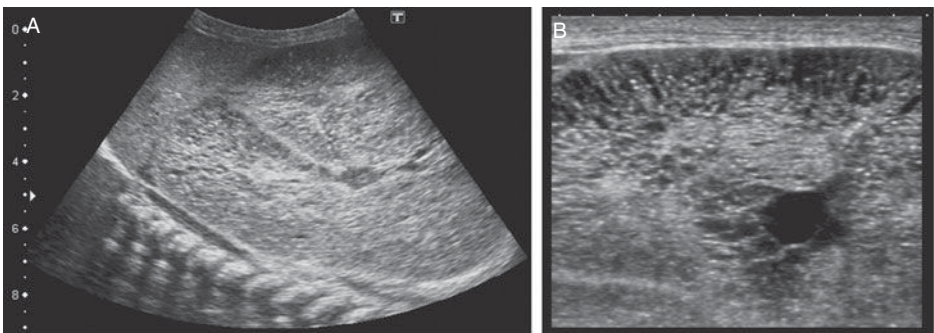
Renal ultrasound of a baby with ARPKD. Symmetrically enlarged echogenic kidneys (A) with fusiform dilations of collecting ducts and distal tubules arranged radially throughout the renal parenchyma from medulla to cortex (B).
